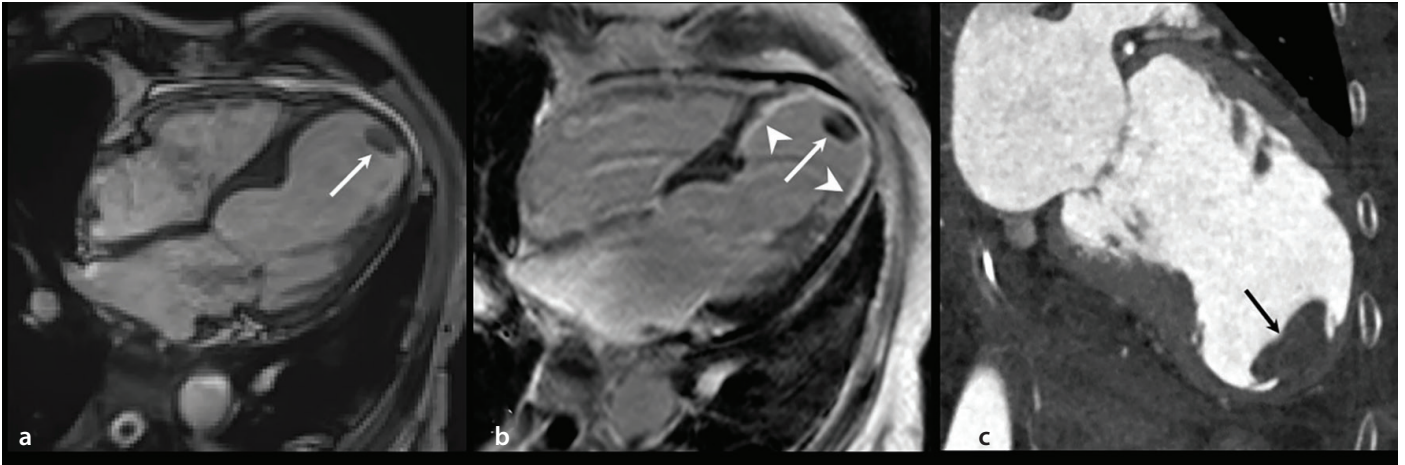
True LV aneurysm in a 75-year-old woman with a history of reperfused STEMI. (a–c): Four-chamber cine (a) and LGE-CMR images (b) and a two-chamber MPR CT image (c) show an apical aneurysm of the left ventricle with transmurally delayed enhancement (b, arrowheads) and an apical thrombus (arrows). STEMI, ST-segment elevation myocardial infarction; LV, left ventricular; MPR, multiplanar reformation; CMR, cardiac magnetic resonance; CT, computed tomography; LGE, late gadolinium enhancement.
